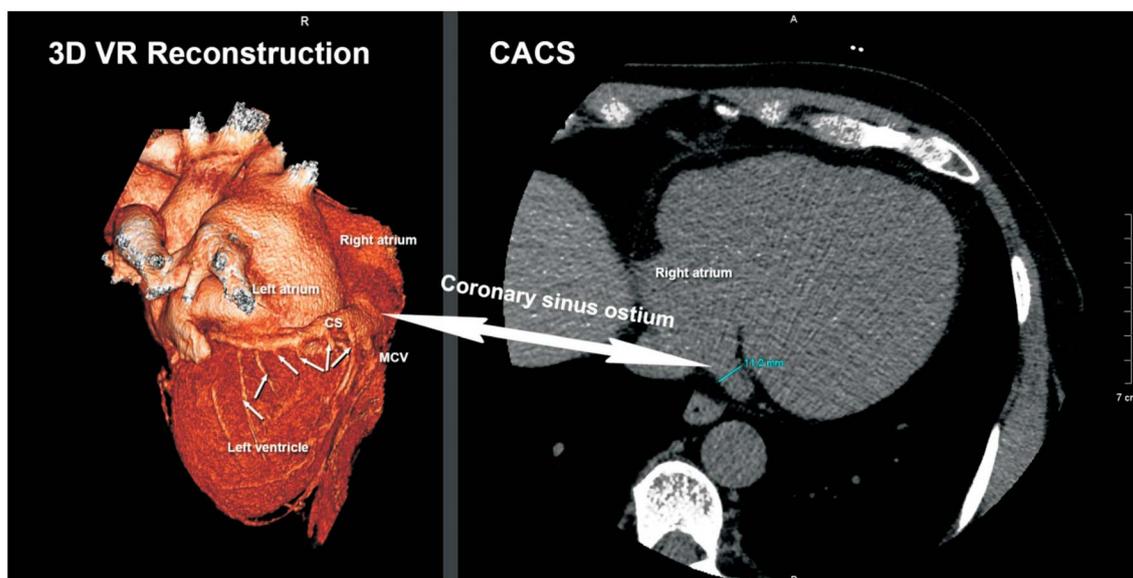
Comparison of cardiac computed tomography in 3D volume rendering with a CACS examination. CACS, coronary artery calcium score; CS, coronary sinus; MCV, middle cardiac vein.
